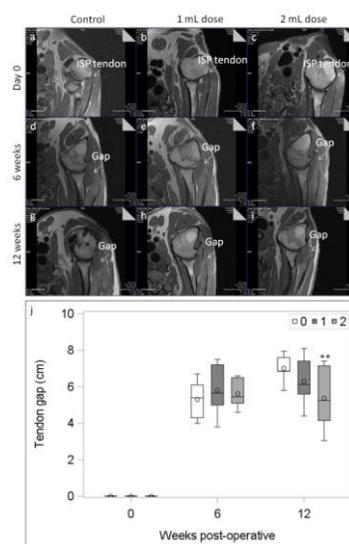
MRI assessment.
